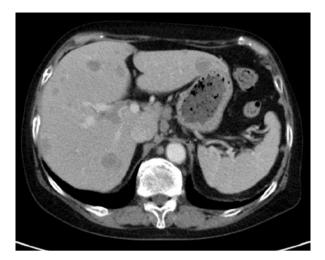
Enhanced CT image in a RA patient with methotrexate-associated lymphoproliferative disorder
